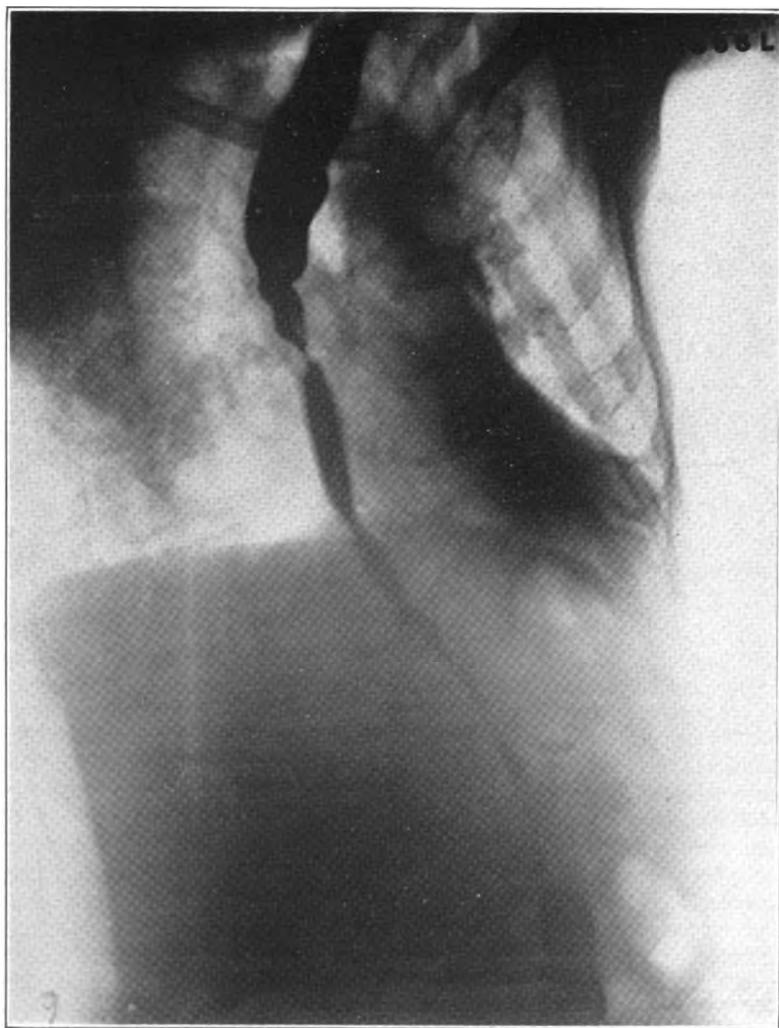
Radiograph of esophagus, showing obstruction in lower third.
